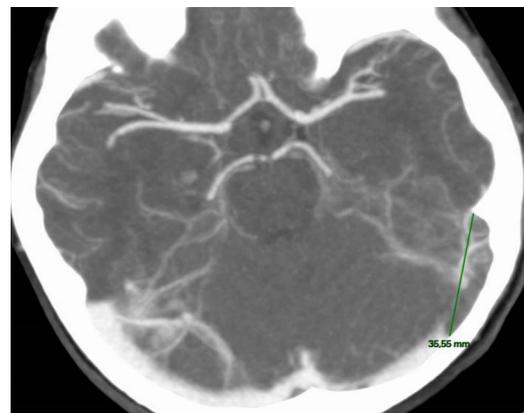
Contrast-enhanced head CT scan, parenchymal window setting, on postoperative day 1. Thrombosis extending to the distal two-thirds of the left lateral sinus. Good patency of the contralateral lateral sinus.
